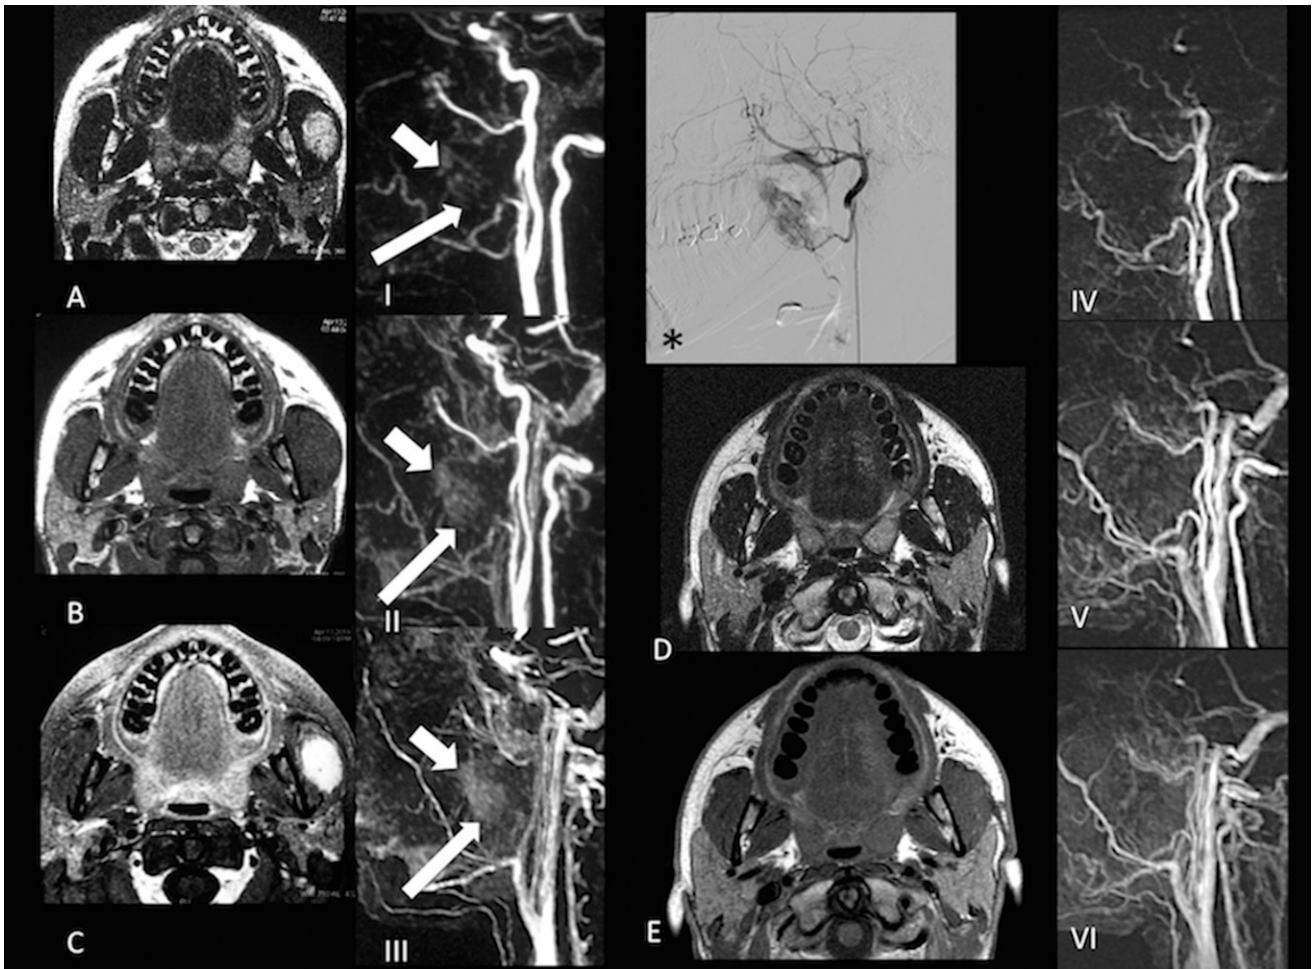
A 28-year-old girl (Patient 5) with painful mastication in the presence of a tumefaction on the left cheek. MRI shows an oval lesion with diffuse enhancement post-gadolinium (a–c). (I–III) Time-resolved imaging of contrast kinetics (TRICKS) images demonstrate an early arterial enhancement (thick arrows), while the majority of the lesion is characterized by a slow venous enhancement (thin arrows). These findings are confirmed by digital subtraction radiography (*). Post-operative imaging (d, e) shows total removal of the vascular lesion, confirmed by TRICKS images (IV–VI).
